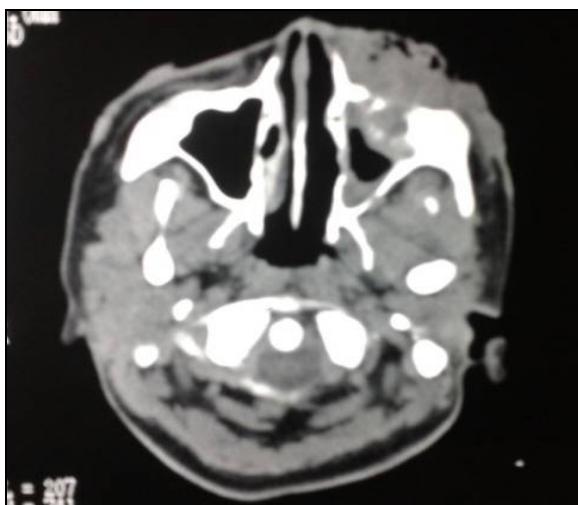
CT image showing involvement of left maxillary antrum and erosion of anterior wall.
